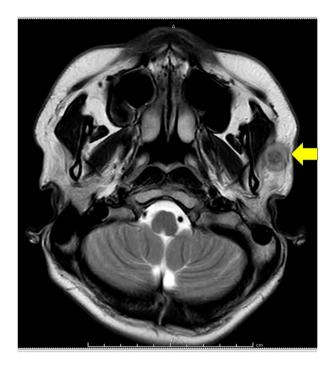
T2-weighted MRI showing a mass in the left parotid gland, indicated using an arrow.
